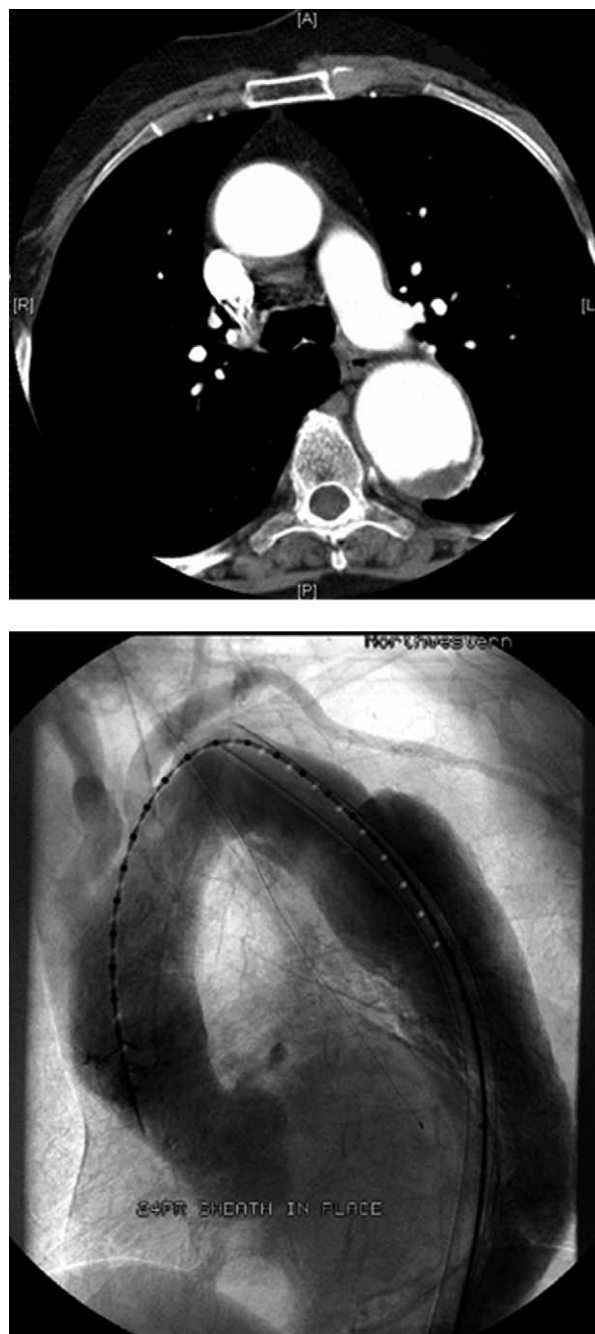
A, Contrast-enhanced computed tomography scan demonstrating aneurysmal degeneration of the descending thoracic aorta. B, Corresponding intraoperative angiogram.
